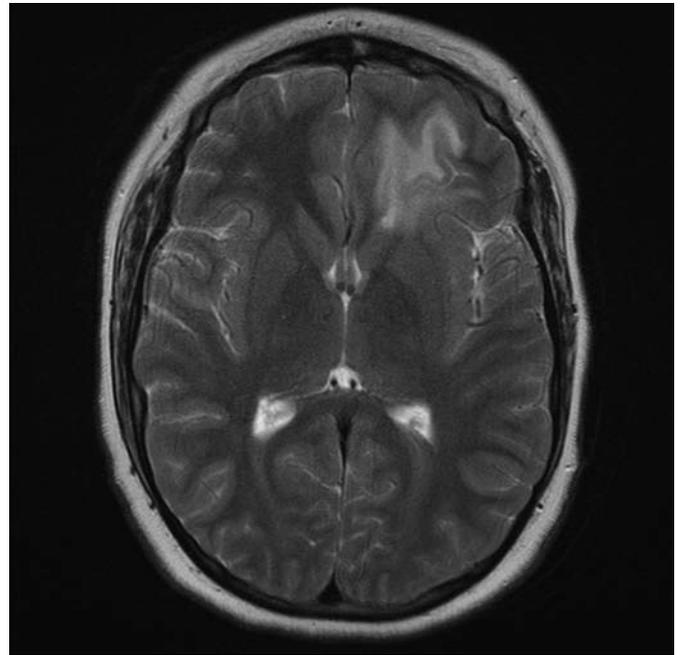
MR image of the head showing high T2/FLAIR signal involving the inferior left frontal lobe, predominantly within the white matter.
